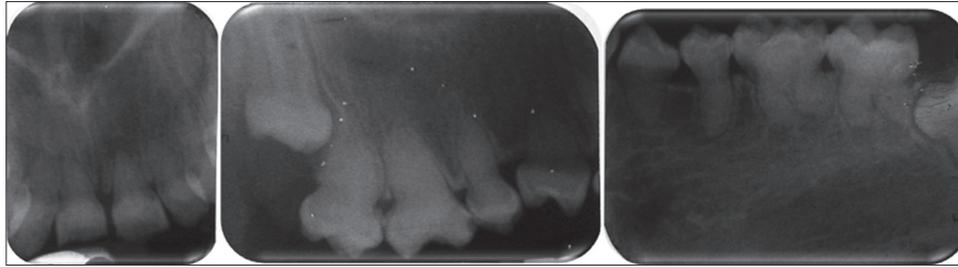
Intra-oral periapical radiograph showing generalized obliteration of coronal and radicular pulp chamber
